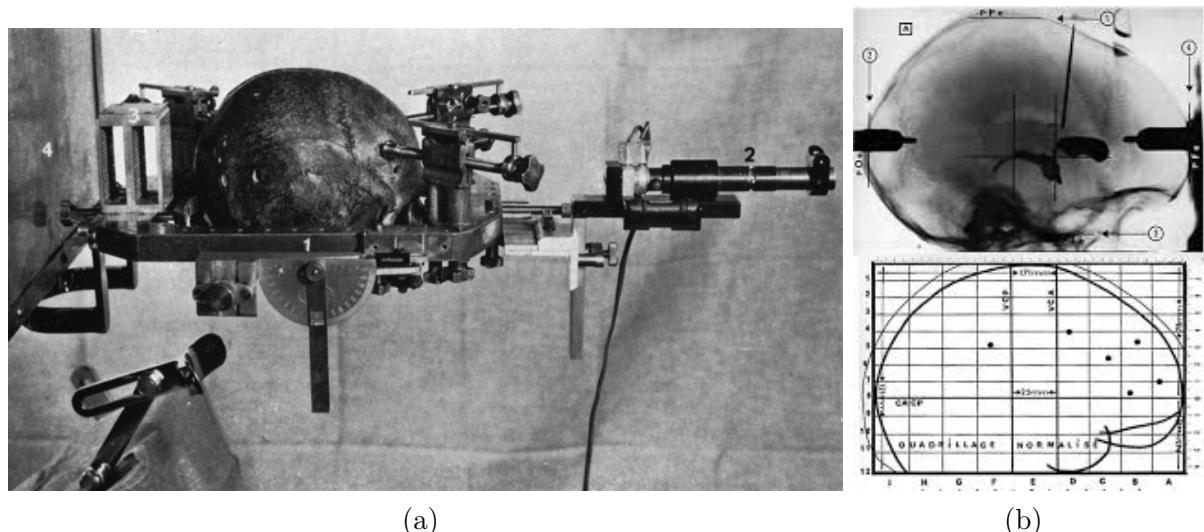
(a) presents Tailarach’s *frame* with x-ray supports and (b) presents an example x-ray image alongside the coordinate system developed by Tailarach (??).
